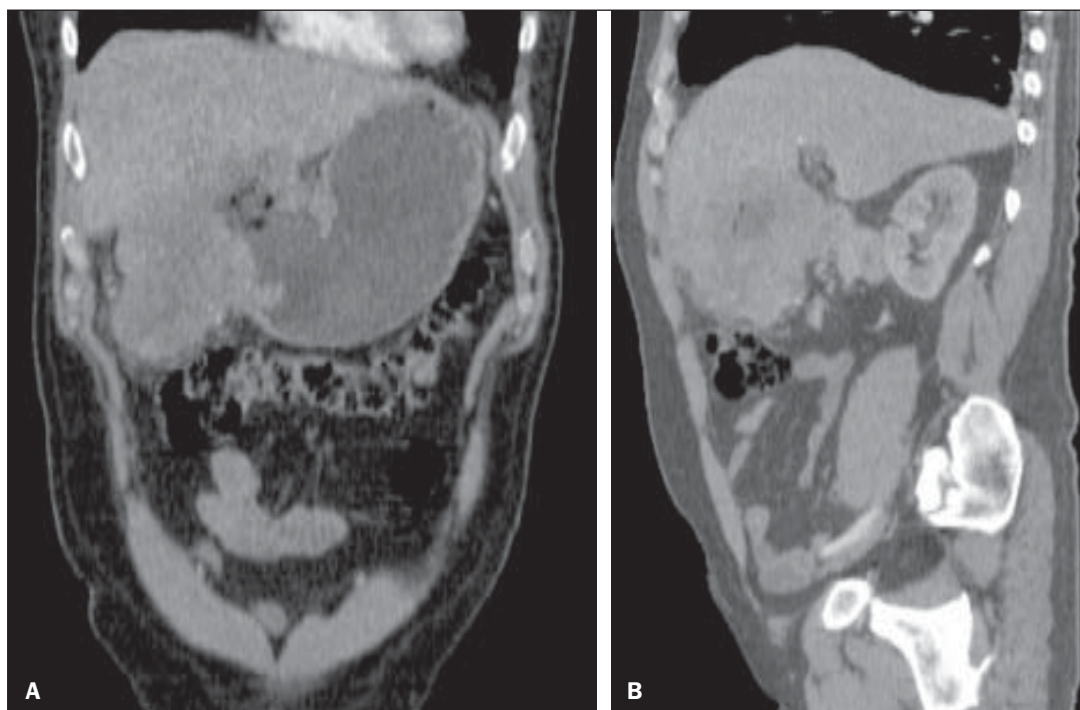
Contrast-enhanced whole abdomen CT, coronal (A) and sagittal reformation (B).
